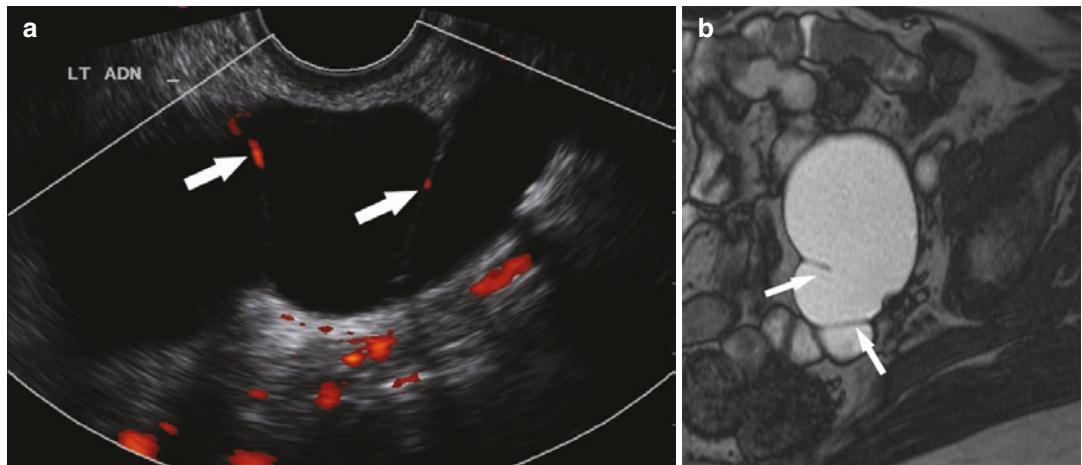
(a) Power Doppler transvaginal US image of a 48-year-old woman with a chronic left hydrosalpinx showing some flow in a fold of the fallopian tube (white arrows). (b) Corresponding T2-weighted MR image
